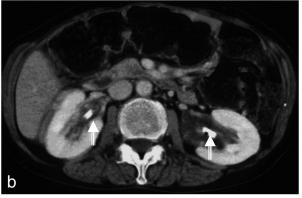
Abdominal CT during hospitalization in the previous hospital (May 5, 2008).
